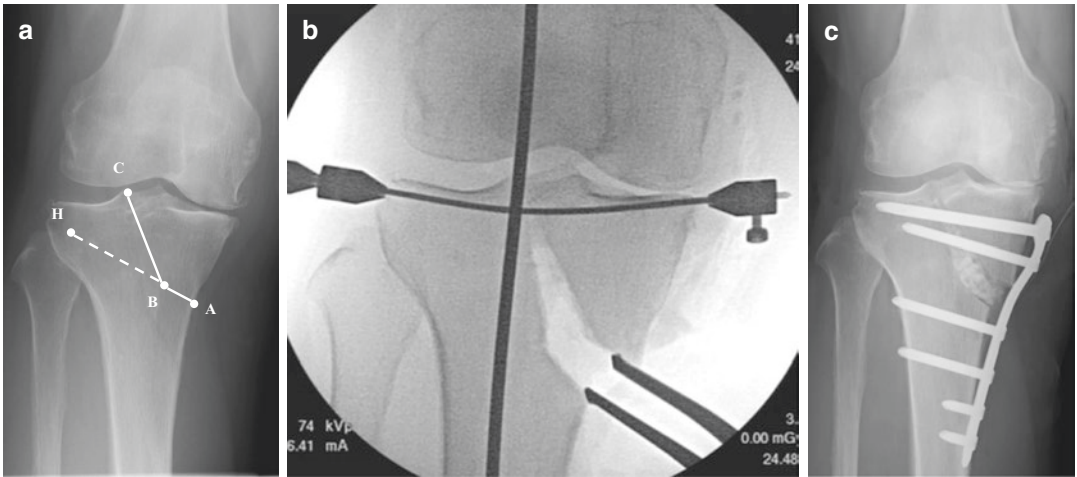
Preoperative radiographs of TCVO. (a) Preplanning. (A) tibial cortex bone surface 4 cm distal from the medial tibial plateau, (B) apex of the L-shaped osteotomy line, (C) lateral intercondylar eminence, (H) lateral hinge point in the OWHTO, solid line; osteotomy line of TCVO, dotted line; virtual line when adding
